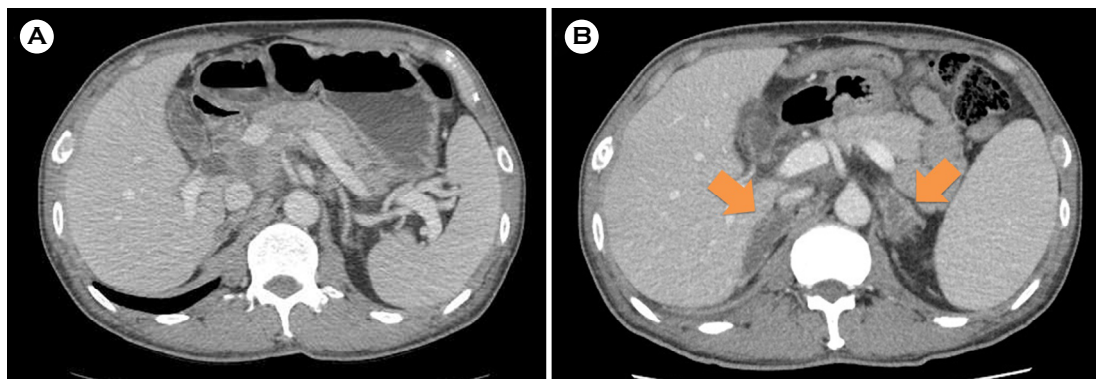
(A) Abdomen and pelvis CT on September, 2013 showed no abnormality on both adrenal glands. (B) However, after 11 months when he revisited to the hospital for recurrent symptoms, abdomen and pelvis CT showed newly appeared low-attenuated thickening of both adrenal glands. This finding suggested unusual infection of adrenal glands such as histoplasmosis or tuberculosis. Also, adrenal lymphoma could be another differential diagnosis.
